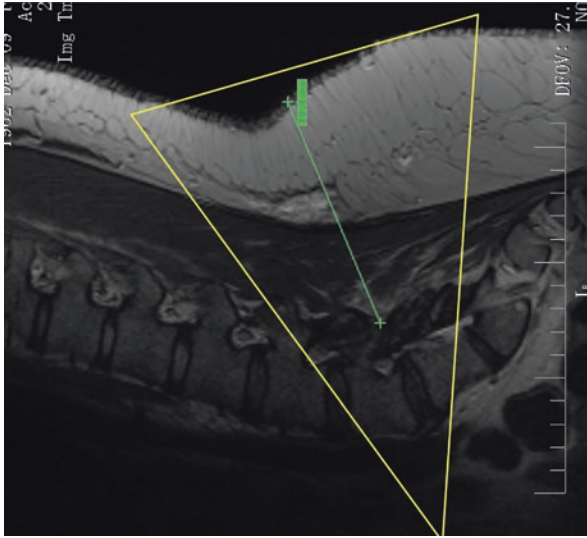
Preoperative evaluation by lumbar MRI, suggesting the extent of the skin incision and muscle dissection necessary to access the disc in an obese patient. The same patient would be able to undergo a minimally invasive fusion through a less than 1 in. incision
